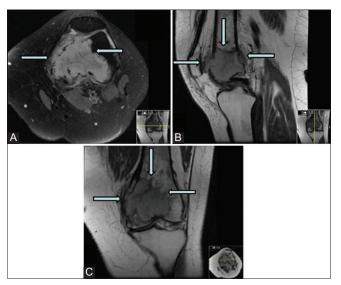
(A-C): Axial T2, (A) sagittal and coronal T1 (B and C) weighted MR images of the knee showing aggressive-appearing medial femoral condyle lesion with cortical breakthrough and extension into the soft tissues
